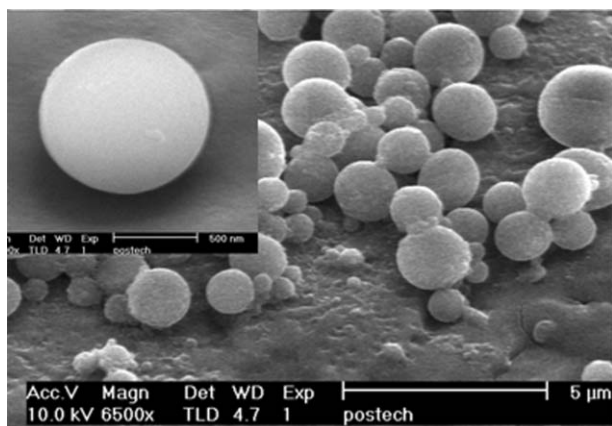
SEM image of the vesicle formed with a CB[8]-stabilized CT complex.
